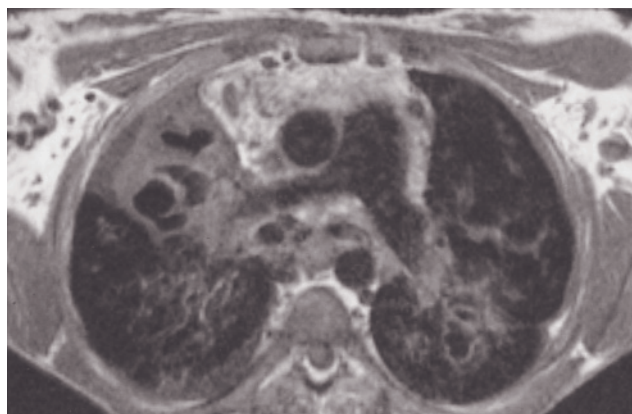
(Continued) T1-weighted image and hypointense on fat-suppressed (c) images, consistent with fatty replacement of the pancreatic parenchyma by adipose tissue. The complete fatty replacement of the pancreas is the most common manifestation of cystic fibrosis. T1-weighted SGE (d, e) and T1-weighted fat-suppressed spin-echo (f) images in a second patient. The pancreas is atrophic and demonstrates fatty replacement. T1-weighted SGE (g, b), T1-weighted fat-suppressed spin-echo (i, j), and gated
